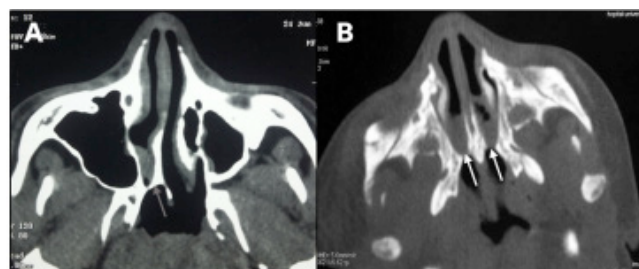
CT scan showing unilateral osseous right side choanal atresia (A) (grey arrow) and bilateral mixed choanal atresia (B) (white arrows)
